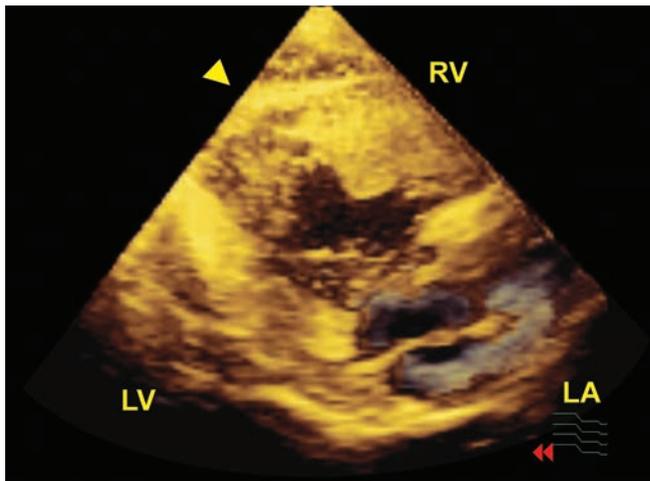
Precise localization of the RV mass (arrowhead) in parasternal long axis view by 3D transthoracic echocardiography.
